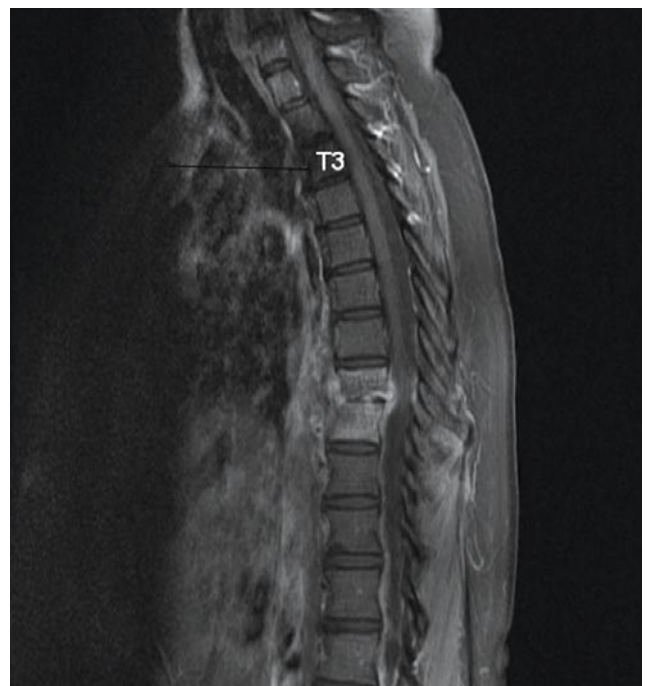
Midsagittal T₁-weighted magnetic resonance imaging scan of same patient (Figure 1) shows tangential line to suprasternal notch intersecting T3 body.
